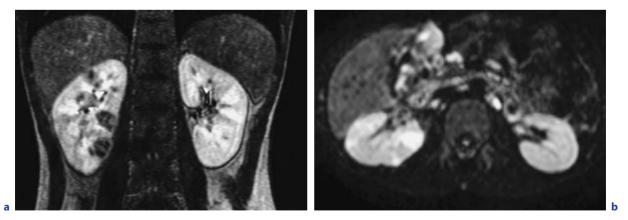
Diffusion weighted imaging and renal abscess. a MR imaging: T1-weighted sequence after Gd enhancement; inflammatory involvement of the right kidney. b MR imaging: diffusion weighted sequence; the abscessed areas highlight.
